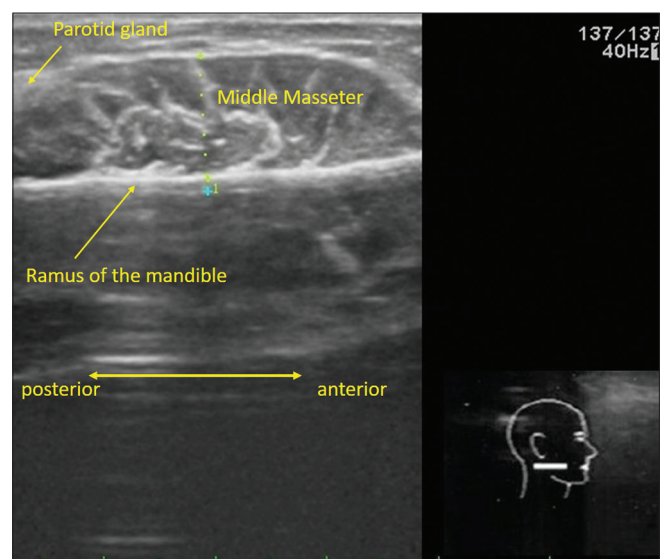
Right masseter muscle (MVC) mid-region USG evaluation. USG: Ultrasound, MVC: Maximum voluntary contraction
